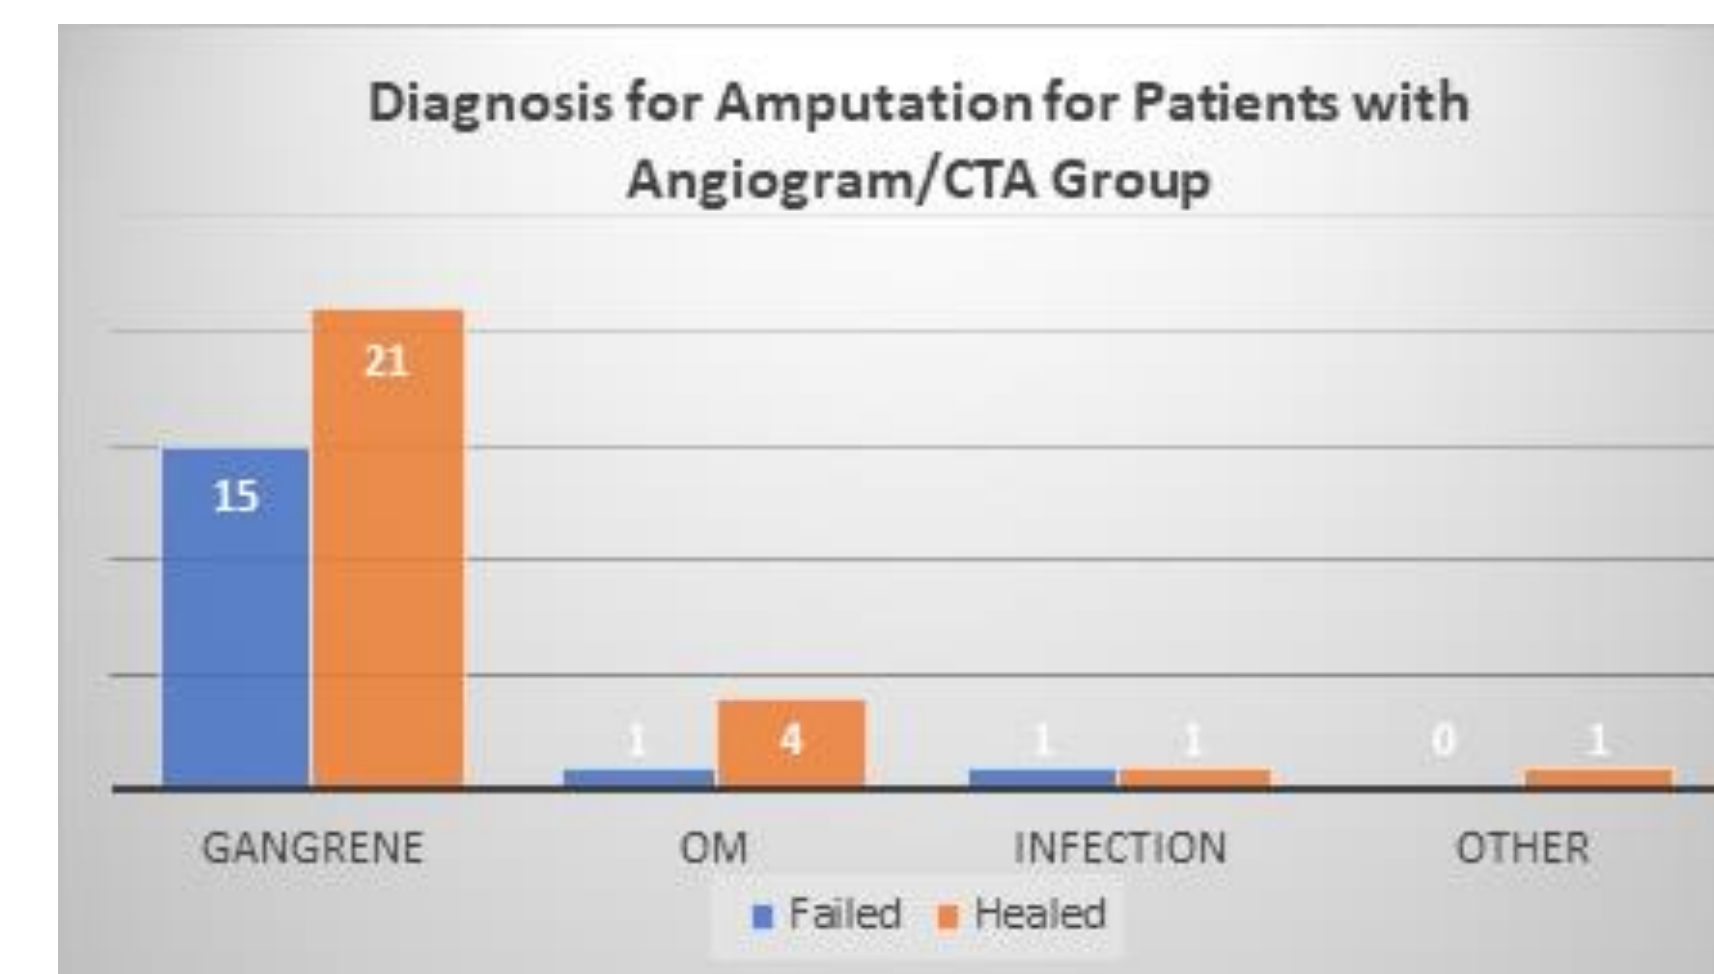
Diagnosis for TMA in for cohort with angiogram/CTA
